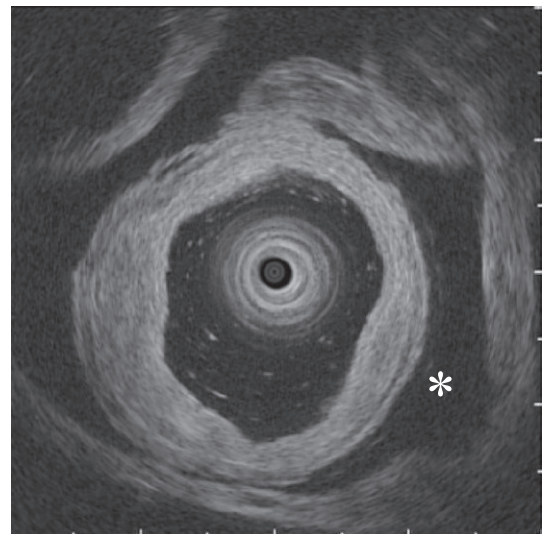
Endoscopic ultrasonography (EUS) image. EUS performed after the resolution of the intussusception shows only edematous ileal mucosa
